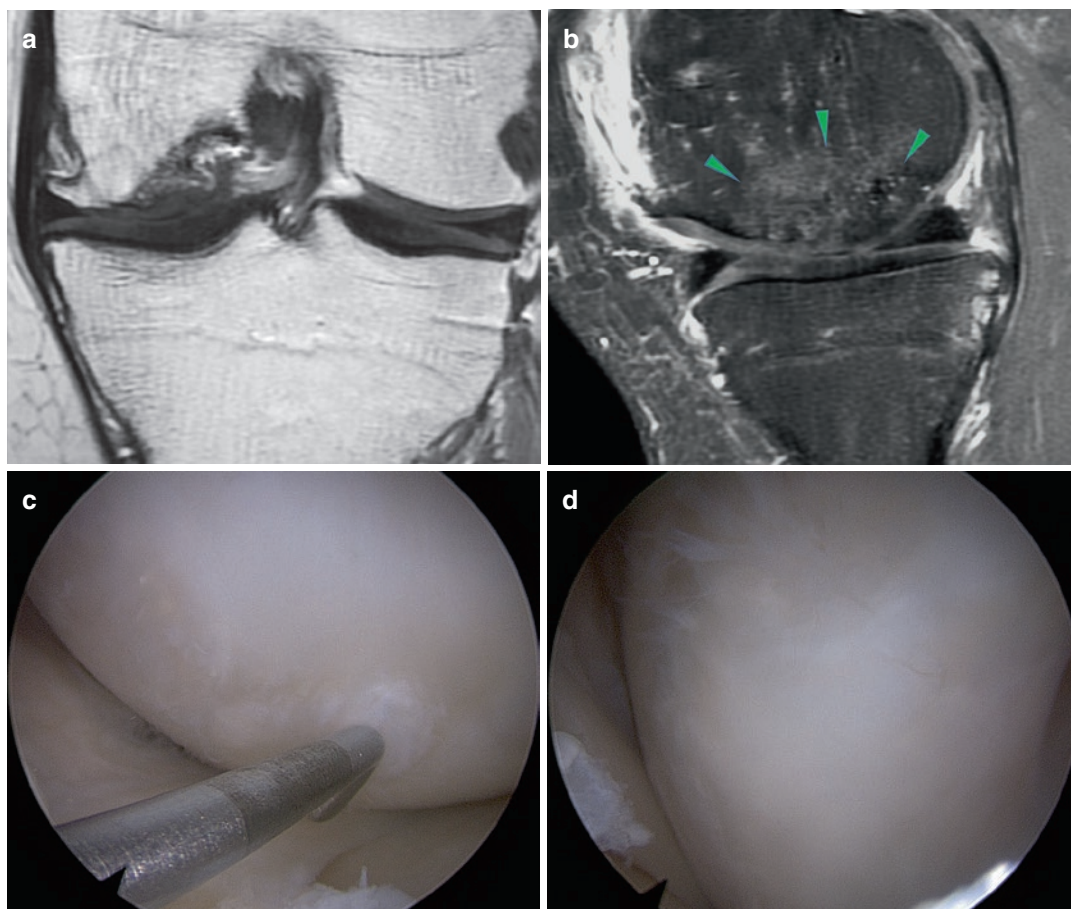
(a) Coronal and (b) sagittal MRI slices (Proton Density Fat Saturation, 3.0 tesla scanner), *green arrowheads* – base of the reconstructed OCL, (c)
